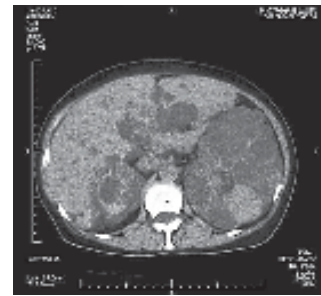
Abdominal CT image. Multiple cysts are seen in the liver and kidneys. High density areas are seen in both kidneys.
